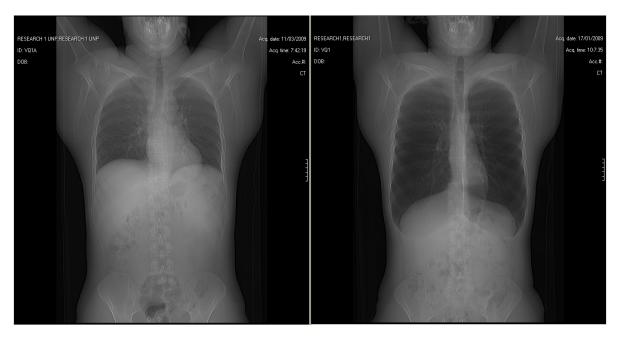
Computed tomography during tidal breathing (left) and following a maximal GI manoeuvre (right) in a competitive freediver. *Significant lung hyperinflation with compression of the mediastinum is evident.*
